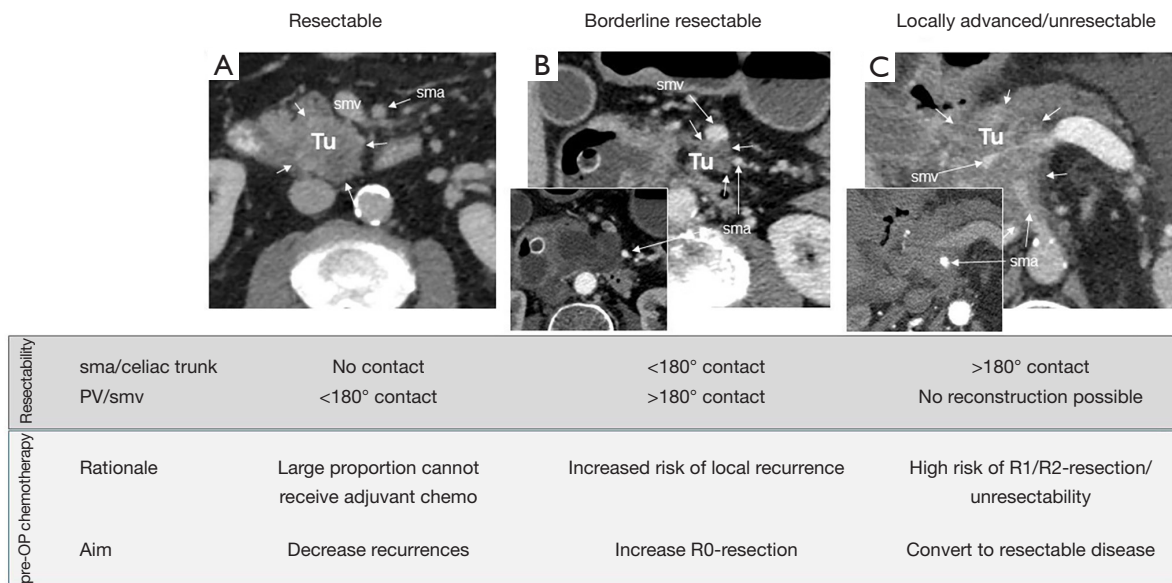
Concept of borderline resectability (the definitions are a summary/interpretation from several international classifications): (A) shows a resectable tumor without contact to sma (superior mesenteric artery) or smv. (B) The CT reveals a tumor contact to the smv (160°) and the sma (borderline resectable). (C) The CT scan shows a tumor which surrounds the sma and occludes the smv confluence (locally advanced, unresectable). Short arrows: tumor. CT, computed tomography.
